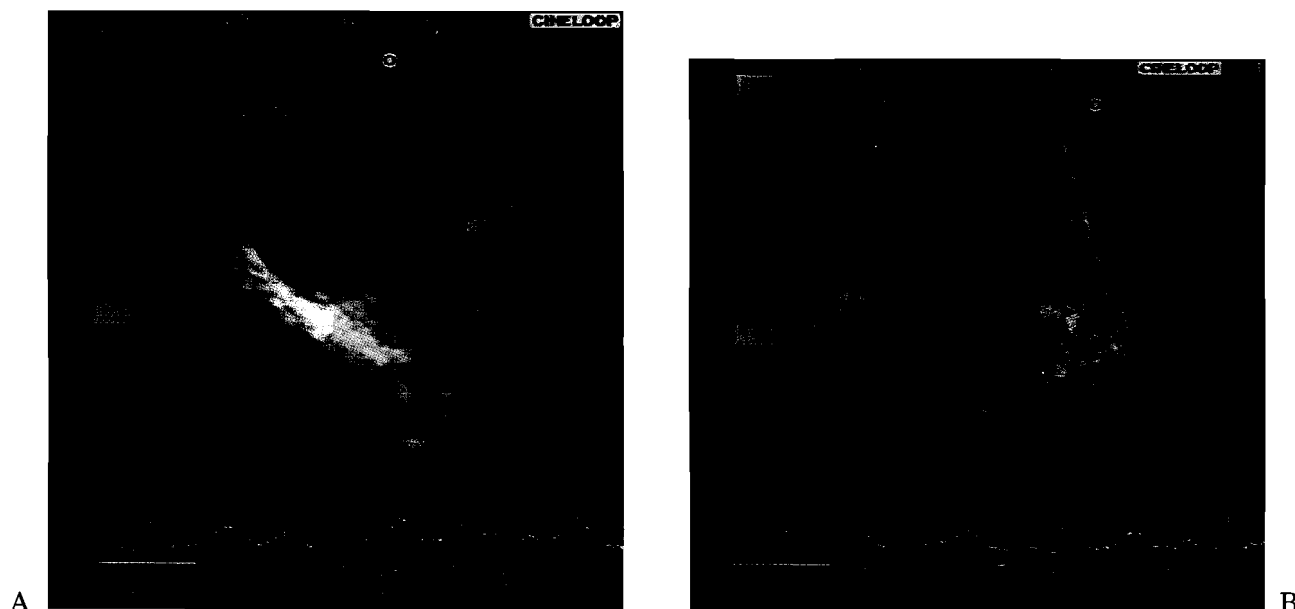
(A) Transesophageal echocardiography, descending thoracic aorta, short-axis view demonstrating a turbulent jet by color Doppler originating from the right side of the aorta and extending posteriorly. (B) Longitudinal view, descending thoracic aorta at the same depth as Figure 1A demonstrating by color Doppler two separate jets originating from the aorta and extending posteriorly. The upper jet is on the right side of the picture.
